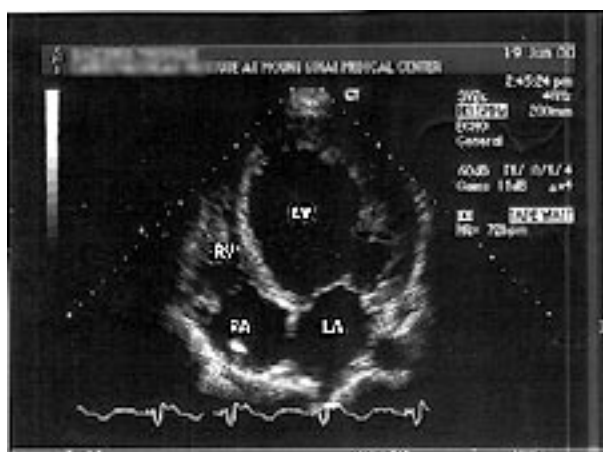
Echocardiography showing severe left ventricular dilatation and fibrosed apical endocardium.
